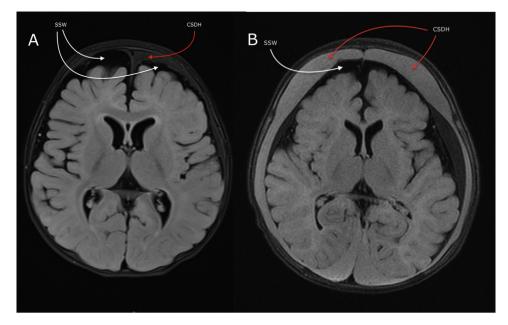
A: MRI of infant in the present study with unilateral CSDH with wide subarachnoid space contralaterally to the SDH. Note that there still is a subarachnoid space (marked "SSW") and that the CCW is the same on both sides. B: MRI of infant in the present study with bilateral CSDH with wide CSDH and visible subarachnoid space. The color version of this figure is available in the online edition. MRI, magnetic resonance imaging; SDH, subdural hematoma; CSDH, chronic subdural hematoma; SSW, subarachnoid space width.
